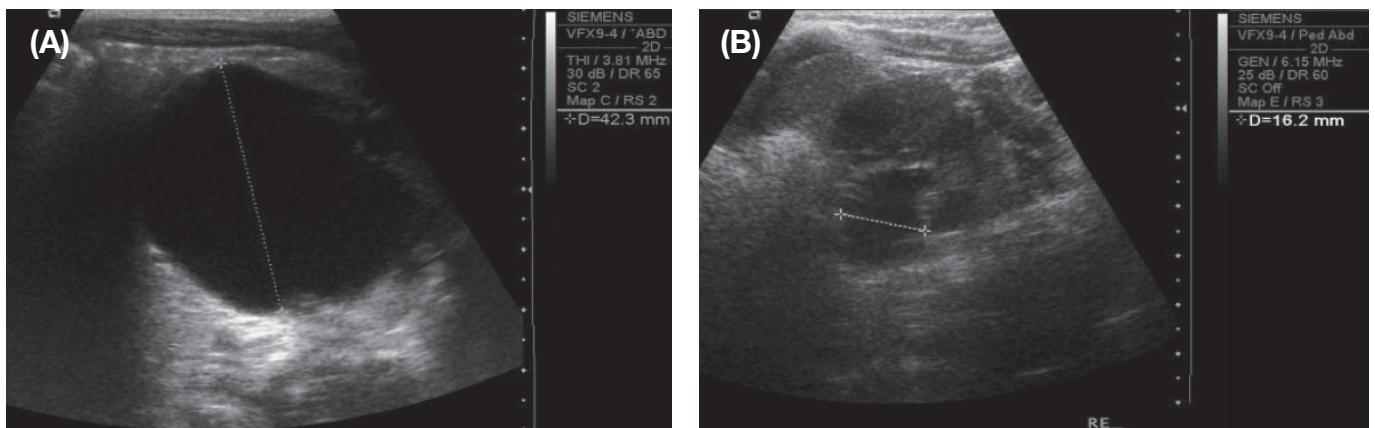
Renal pelvis at ultrasound before (A) and after (B) endoscopic balloon dilatation.
